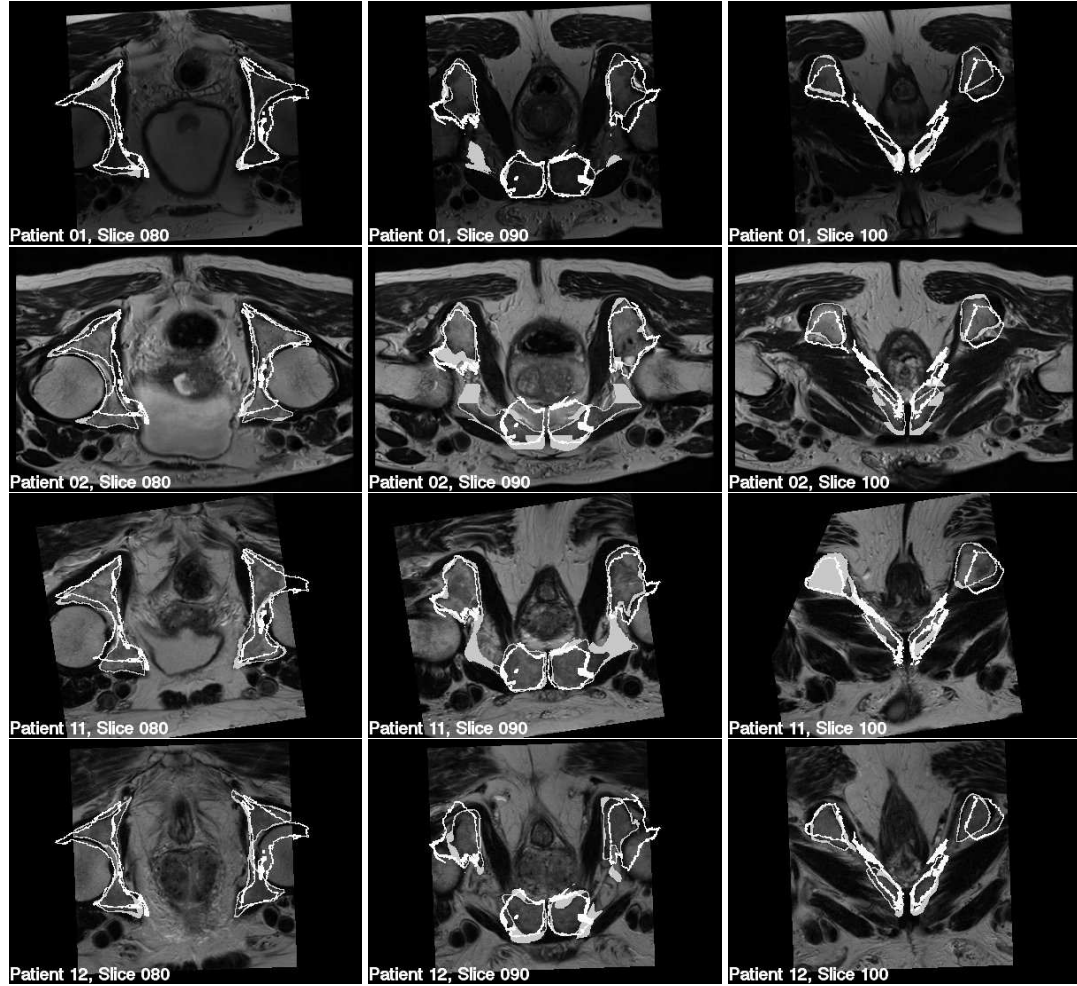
Example slices from each of the four MRI data sets. The manual segmentations are shown in grey, while the shape model propagated segmentations are shown in white. Patient-02 is notably worse than the others. It is also interesting that all data sets fail in the same region to the top right of slice 100, suggesting that this region is not well described by the shape model.
